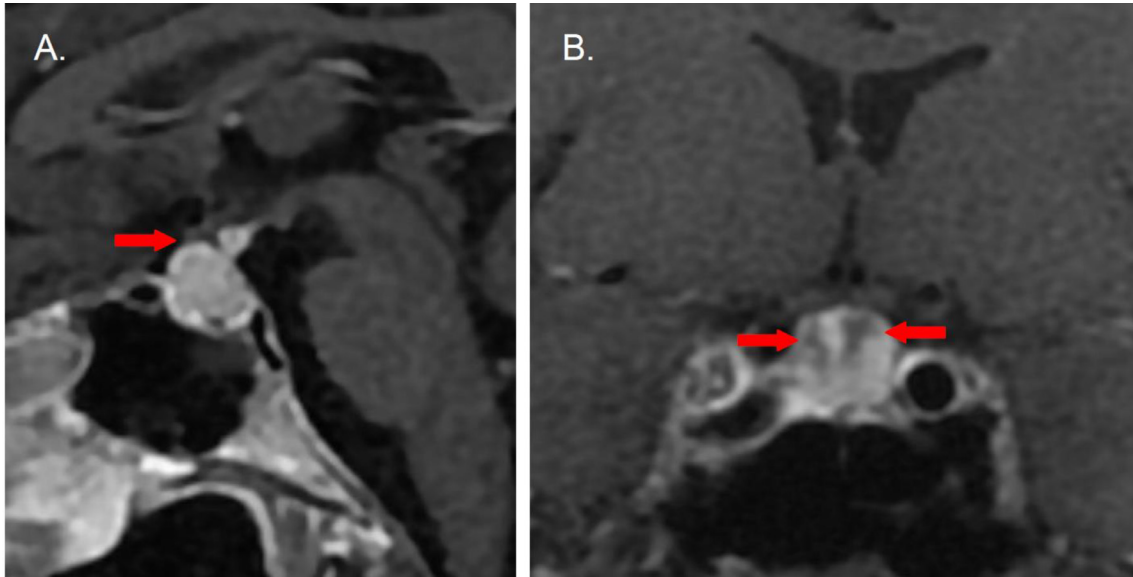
(A) 3D Sagittal CUBE T1 post-contrast MRI sequence shows enlargement of the pituitary gland which contacts the undersurface of the optic chiasm (solid arrow) and proximal aspect of the optic nerves (not shown). (B) Coronal fat-suppressed T1 postcontrast MRI sequence demonstrates a changed enhancement pattern compared with the prior MRI with linear regions of hypoenhancement (solid arrows), but no discrete lesion.
